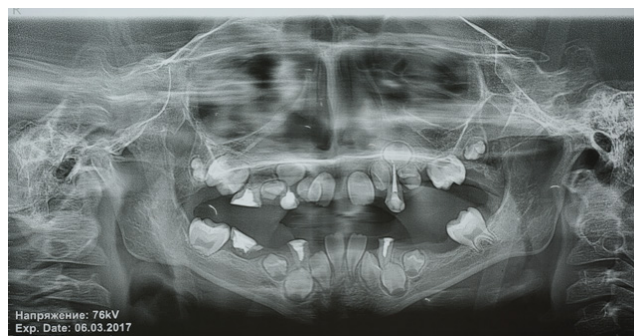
Panoramic X-ray of patient B.D. at the age of 7
